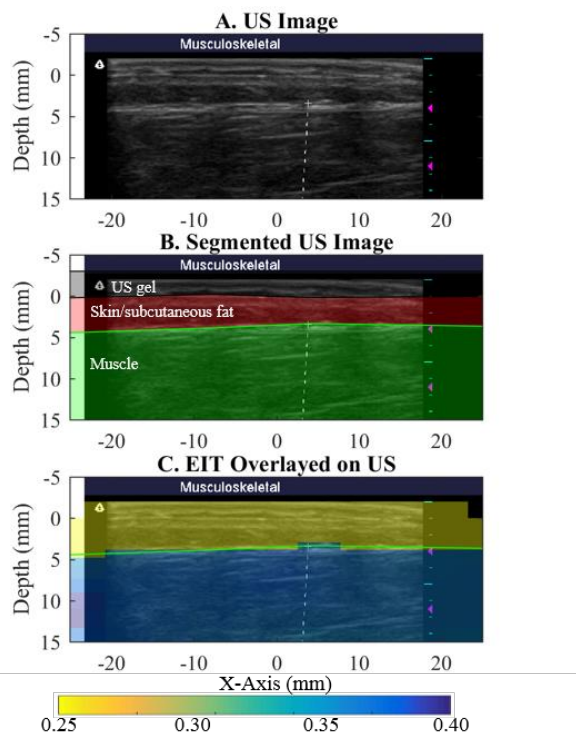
A) Ultrasound image acquired with US/EIT probe, B) Segmented US image, C) overlaid conductivity image.
